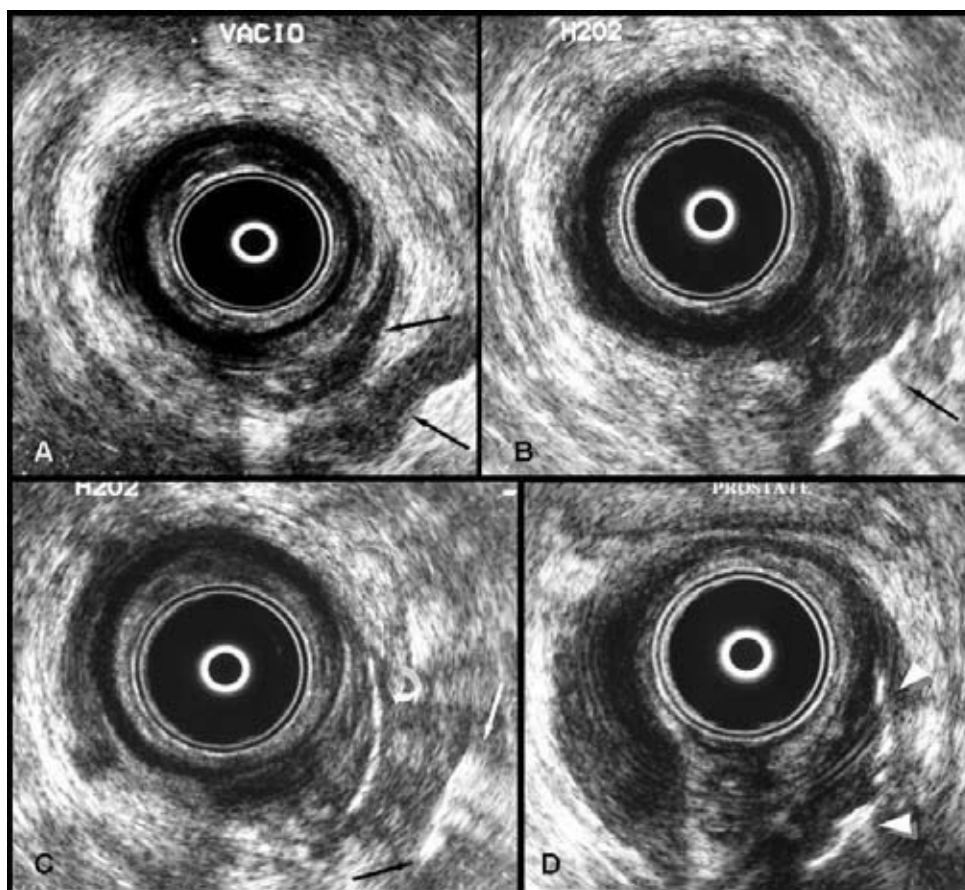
Suprasphincteric fistula. A. Conventional endoanal ultrasound with hypoechoic lesion in the back-lateral intersphincteric plane and left ischio-rectal area (arrows). B. After injecting H_2O_2 , a connection with the abscess located in the ischio-rectal area (arrow) is observed. C and D. An intersphincteric tract (curved arrow at C) and the fistulous extension above the insertion of the elevator muscle of the anus close to the base of the prostate (head of arrow at D) are shown.
